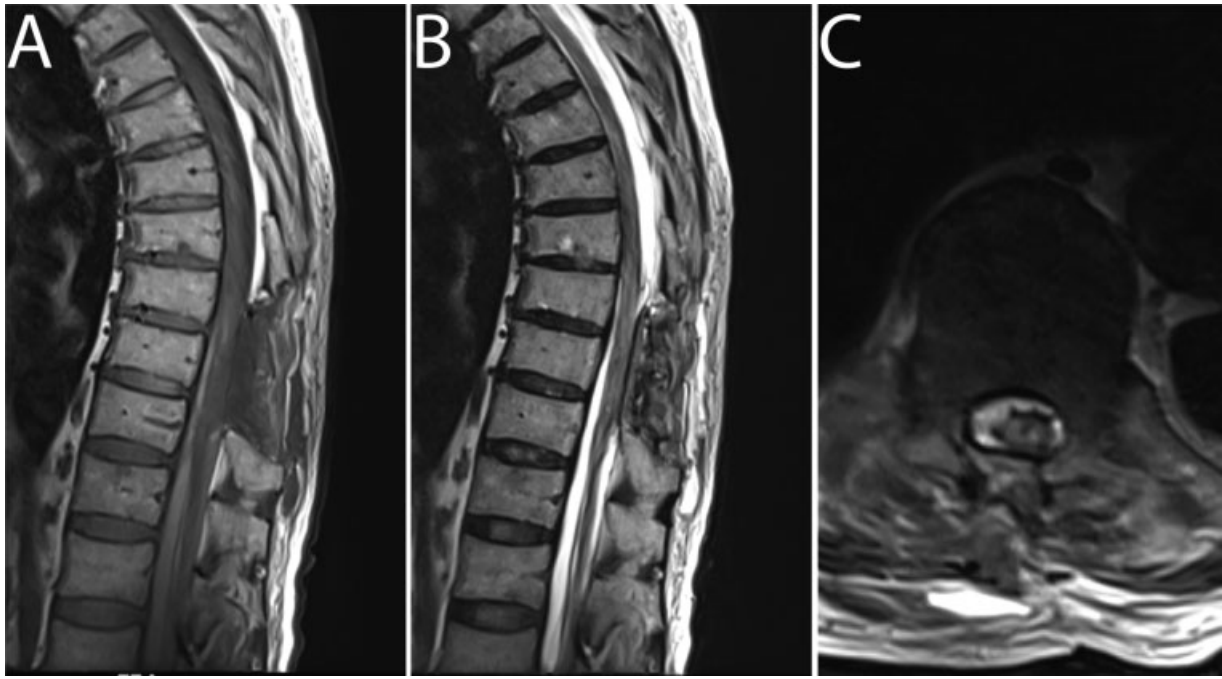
(A) Postoperative sagittal T1-weighted MRI sequence image of the thorax, demonstrating evacuation of focal hematoma. (B, C) Postoperative sagittal and axial T2-weighted MRI sequence image of the thorax, demonstrating circumferential hyperintense signal of CSF surrounding the spinal cord, reflecting effective decompression.
